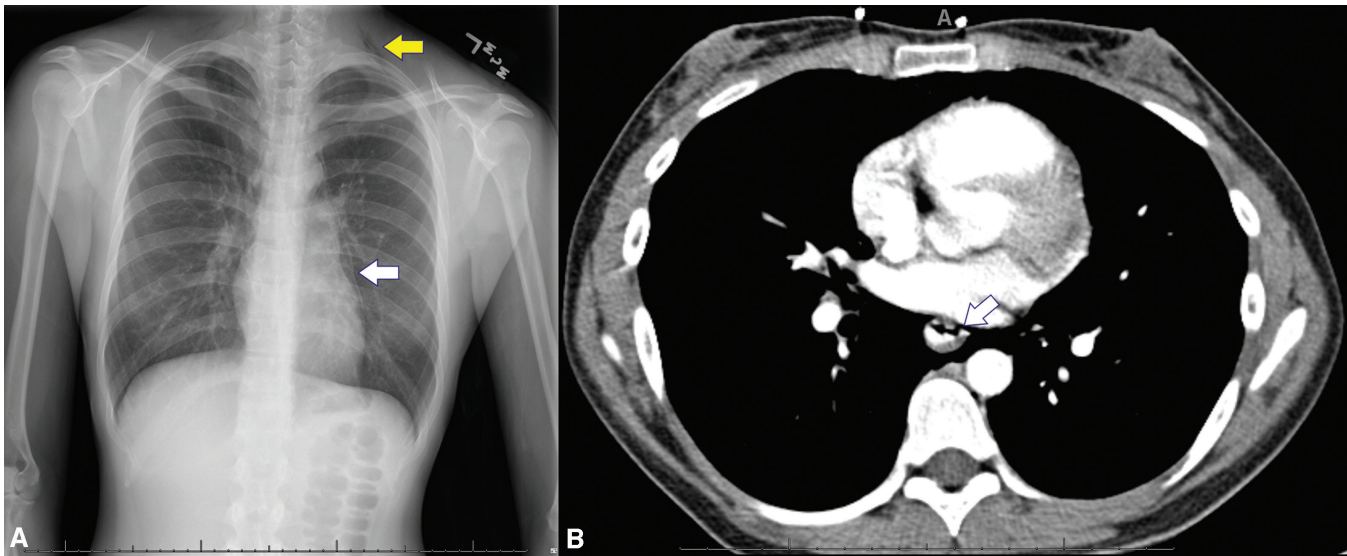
Chest radiograph and subsequent CT scan in a patient with a history of repeated vomiting after alcohol binge. *A:* Upright chest radiograph demonstrating pneumomediastinum with subcutaneous emphysema of the neck (*yellow arrow*) and pneumopericardium (*white arrow*). *B:* Axial CT image of the chest demonstrating a subtle area of focal disruption/tear (*arrow*) in the left anterolateral distal esophagus, which is consistent with Boerhaave syndrome.
